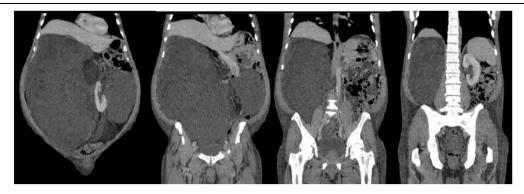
CT Volumous Retroperitoneal Lesion 31.0 X 30.0 cm in its Largest Axial Diameters. The Injury Compresses and Displaces. The Right Hepatic Lobe in A Cranial Direction and Displaces the Right Kidney (Yellow Circle), The Pancreas and Small Loops to the Left. Left Kidney (Red Circle).
